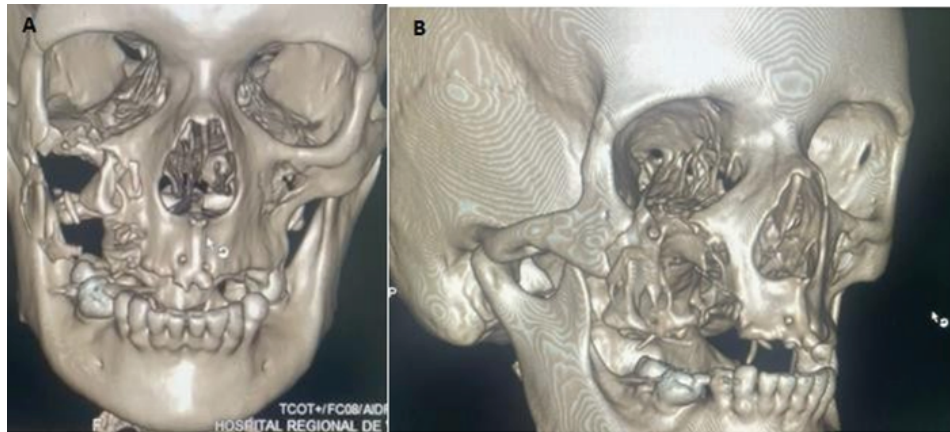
Computed tomography (CT) imaging of the face. A: Frontal view of the CT; B: Lateral view of the CT.
